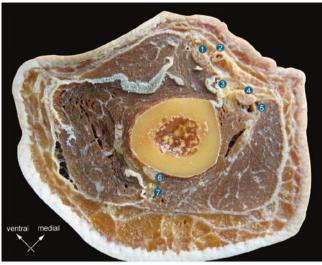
Section of the arm at the middle third-distal third junction of the arm with materialisation of ultrasound beam
